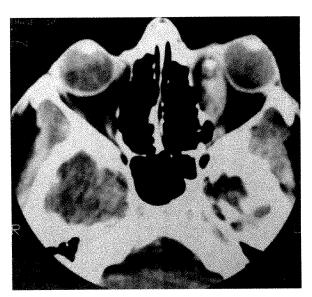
(Reifler, Leder, and Rexford). Case 2. Computed tomographic scan showing proptosis and spill-over of left medial rectus muscle inflammation into the surrounding orbital fat. Focal radiodense area adjacent to infiltrated left medial rectus tendon correlated with pseudoencapsulated orbital hemorrhage found at surgical exploration, but a phlebolith was not found.
